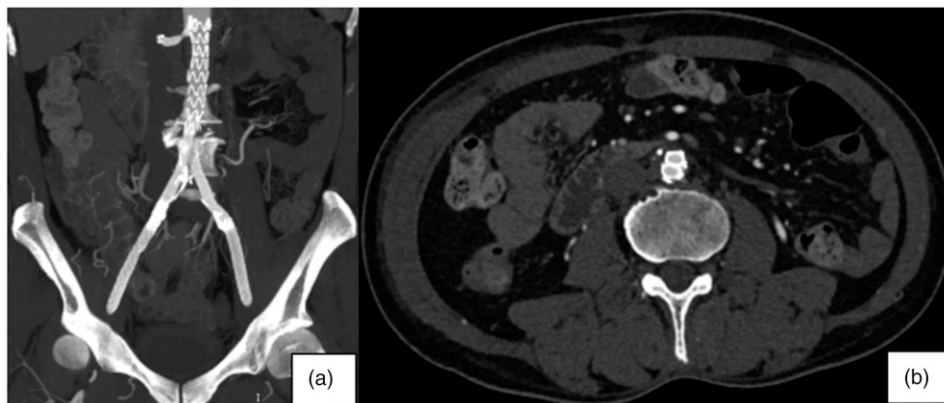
Postoperative computed tomography angiography of a 58-year-old male patient demonstrated complete revascularization of the juxtarenal aortoiliac occlusion.
